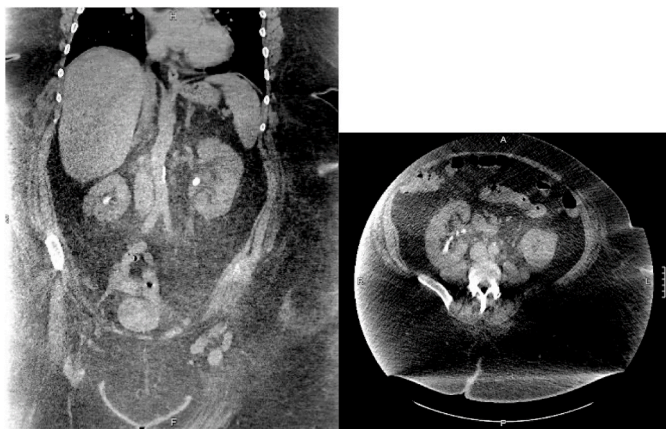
Coronal and axial CT images demonstrating bilateral renal stones.
